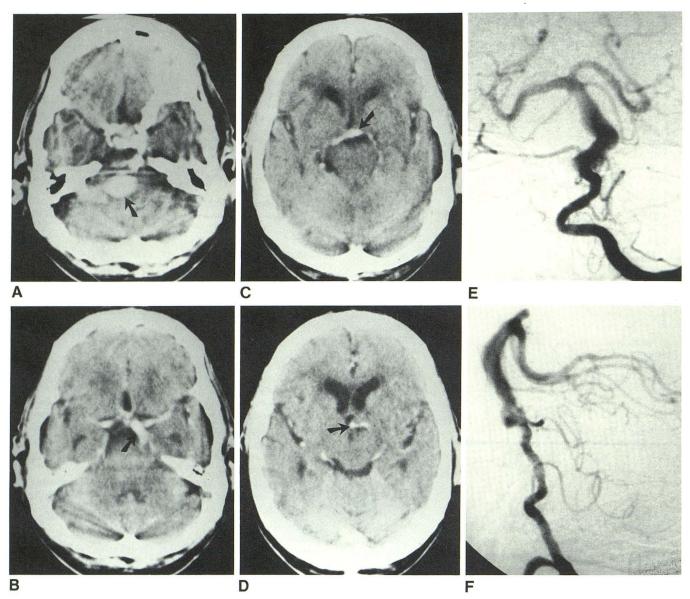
Discrepancy between diameter of basilar artery (*arrows*) as seen on serial CT sections and angiography. A, Marked ectasia of proximal basilar artery. B, Moderate ectasia at level of suprasellar cistern. C and D, More distal parts of basilar artery appear only mildly ectatic. Anteroposterior (E) and lateral (F) intraarterial digital subtraction angiograms reveal atherosclerotic plaguing
